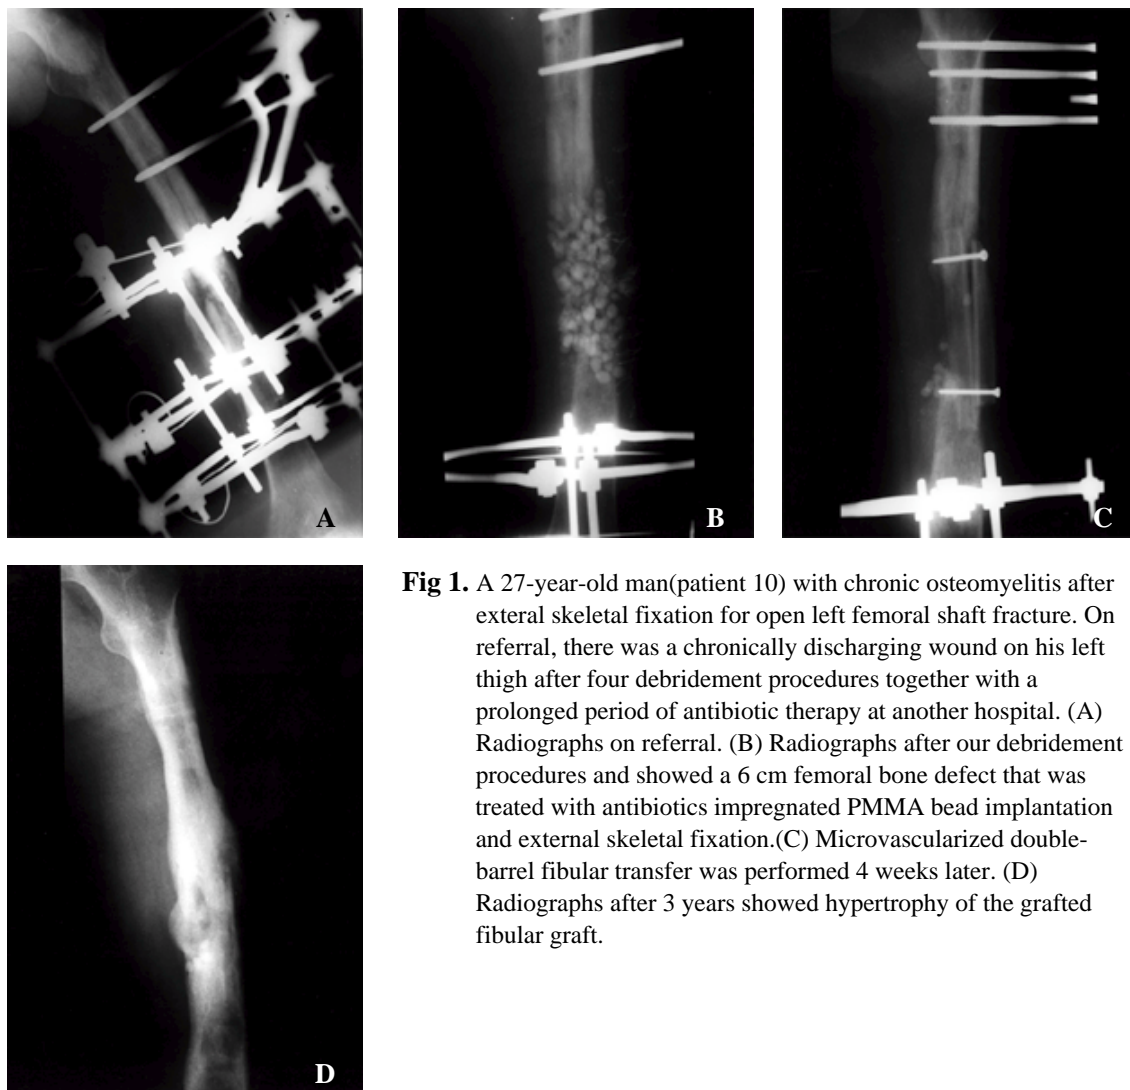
A 27-year-old man(patient 10) with chronic osteomyelitis after external skeletal fixation for open left femoral shaft fracture. On referral, there was a chronically discharging wound on his left thigh after four debridement procedures together with a prolonged period of antibiotic therapy at another hospital. (A) Radiographs on referral. (B) Radiographs after our debridement procedures and showed a 6 cm femoral bone defect that was treated with antibiotics impregnated PMMA bead implantation and external skeletal fixation.(C) Microvascularized double-barrel fibular transfer was performed 4 weeks later. (D) Radiographs after 3 years showed hypertrophy of the grafted fibular graft.
